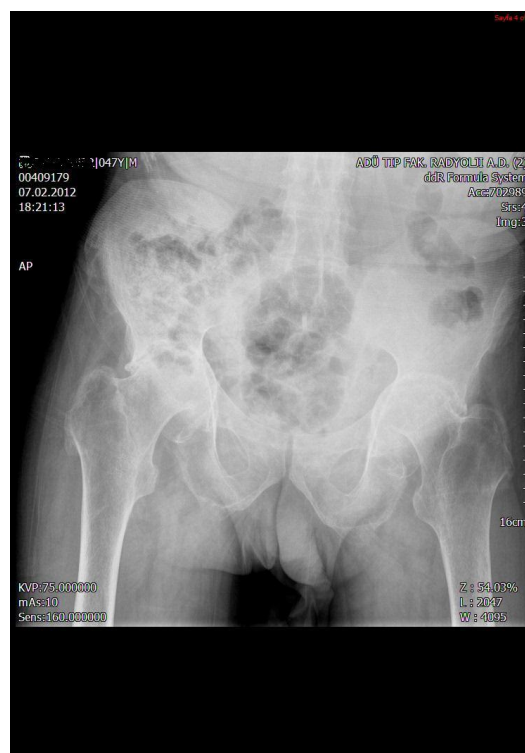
Anterior-posterior pelvic X-ray film. Bilateral Grade 4 sacroiliitis and severe diffuse narrowing hip joints
